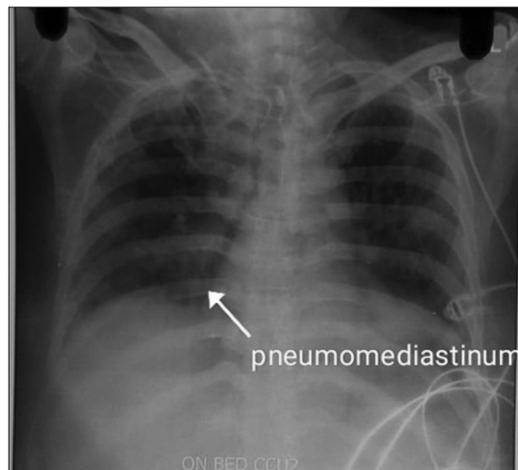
Chest X-ray posteroanterior view white arrow showing pneumomediastinum
